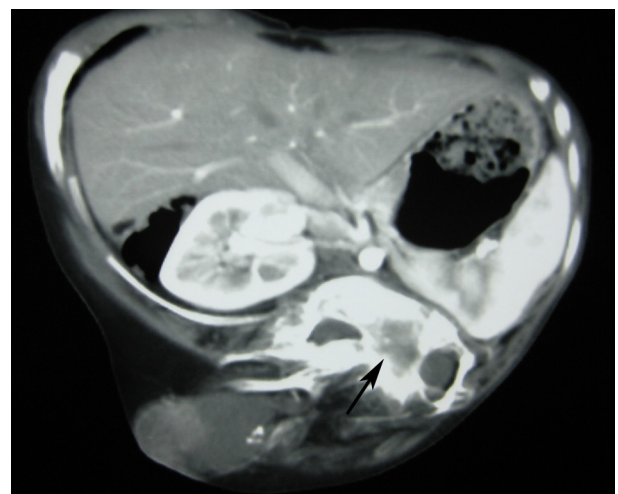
CT scan showed diastematorrhachia and diastematomyelia in the thoracolumbar region (arrow).
